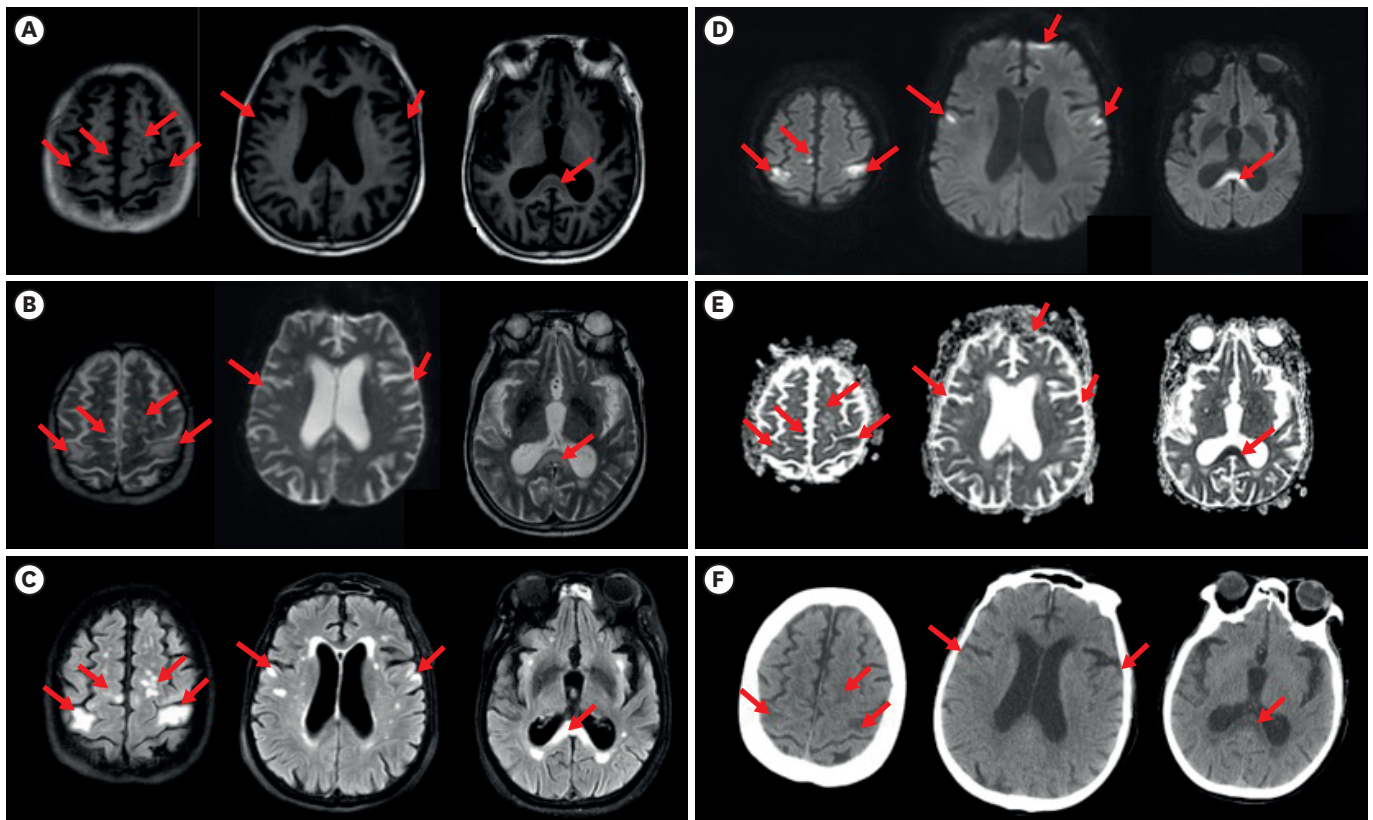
Axial images of brain MRI and CT when MBD was diagnosed. MRI showed hypointensities in T1WI (A), hyperintensities in T2WI (B) and hyperintensities in T2 FLAIR (C) in the body, splenium of corpus callosum, both precentral gyrus and both frontal cortex. Corresponding region in DWI (D) showed hyperintensities with a decreased ADC image (E). Corresponding region in CT (F) showed hypointensities (arrow in A-F). MRI, magnetic resonance; CT, computed tomography; MBD, Marchiafava-Bignami disease; T1WI, T1-weighted image; T2WI, T2-weighted image; FLAIR, fluid attenuated inversion recovery; DWI, diffusion-weighted magnetic resonance image; ADC, apparent diffusion coefficient.
